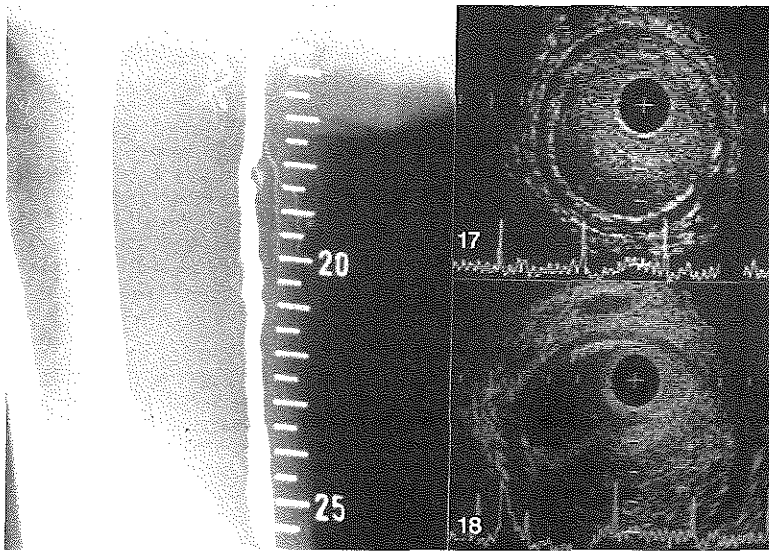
Angiogram with radiopaque ruler and intravascular ultrasound cross sections of the superficial femoral artery obtained before balloon angioplasty. Intravascular ultrasound confirmed the sites of normality (level 17) and abnormality (level 18) as assessed angiographically. The three-layered appearance of the vessel wall indicates its muscular nature. Calibration=1 mm.
